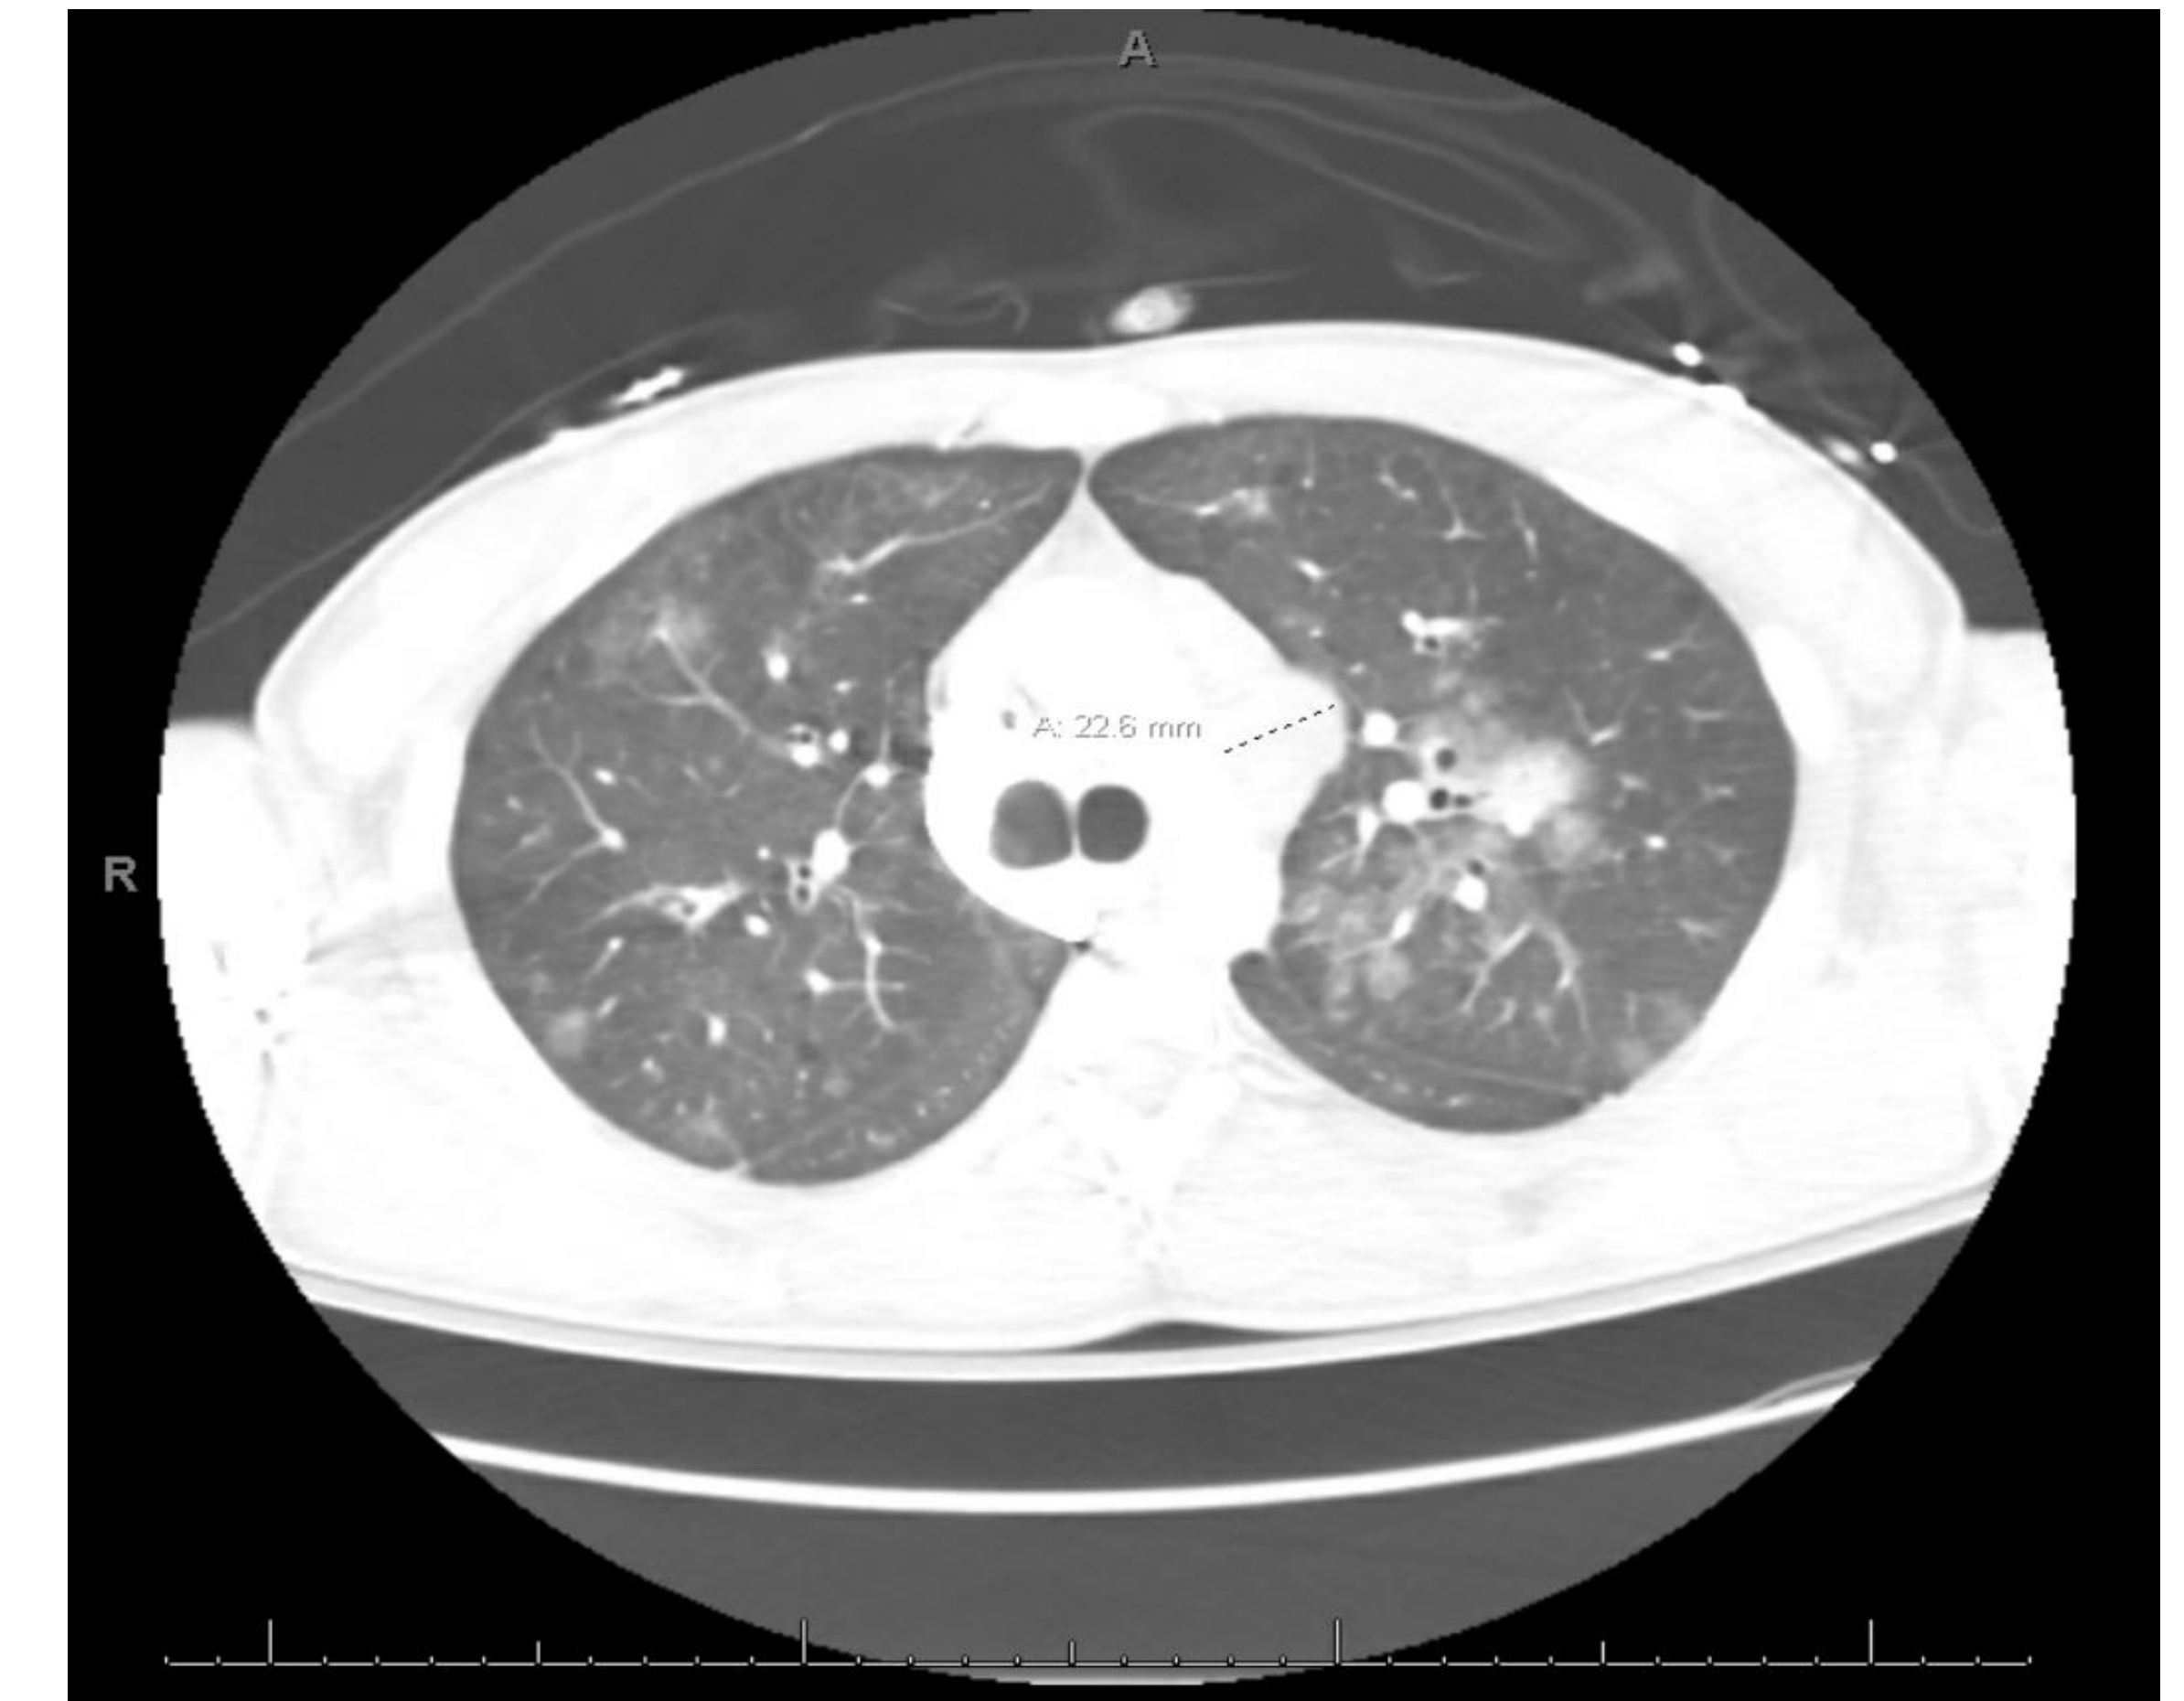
Chest CT – multifocal, bilateral ground glass and nodular opacities with cystic cavities. Mediastinal and hilar lymphadenopathy.
